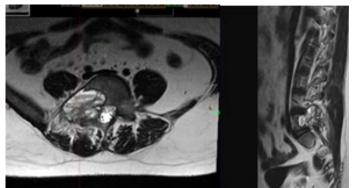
Spine MRI/ November 2022-Evidence of a tumor process on the right involving the body and right pedicle of the fifth lumbar vertebra (L5), exerting antero-lateral compression on the dural sac and on the nerve root at that level, with imaging features of aneurysmal bone cyst.
